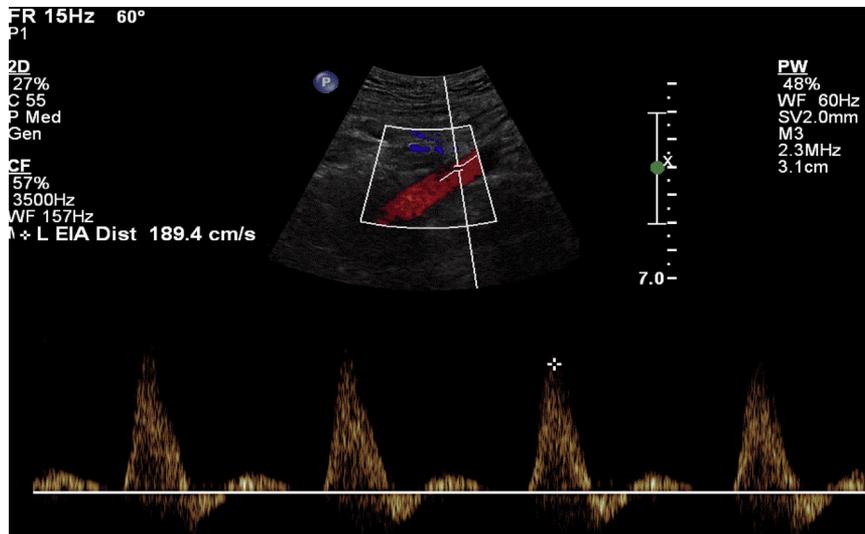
Postoperative duplex ultrasound demonstrated patent left external iliac artery reconstruction without evidence of stenosis or significant velocity elevations. Left external iliac artery waveforms and velocities on 3-month follow-up appointment. Duplex imaging demonstrated widely patent external iliac artery with multiphasic waveforms and normal velocities.
